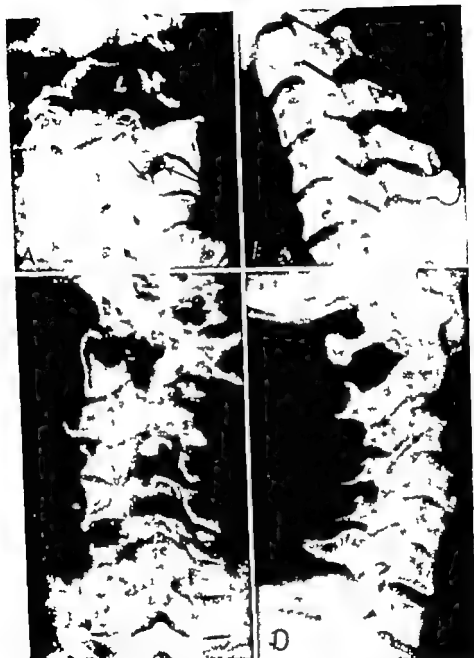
Lateral-oblique views, which show the posterior articulations. The patient shown in (A) has had a partial facetectomy at C5 and 6. The short arrow points to a fragment of bone which was not removed. This patient's symptoms were not relieved by the operation. The radiographs (C) and (D) are those of a patient who had received a neck injury in childhood. There is bony fusion between the posterior portions of the bodies of C5 and 6, and an avulsion of the spinous process of C5 as shown in (D). The lateral oblique (C) shows that there is no bony fusion of the facets.
